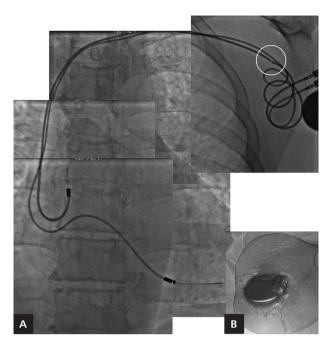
Postero-anterior X-ray view (A) and pacemaker pocket region conditions (B)
